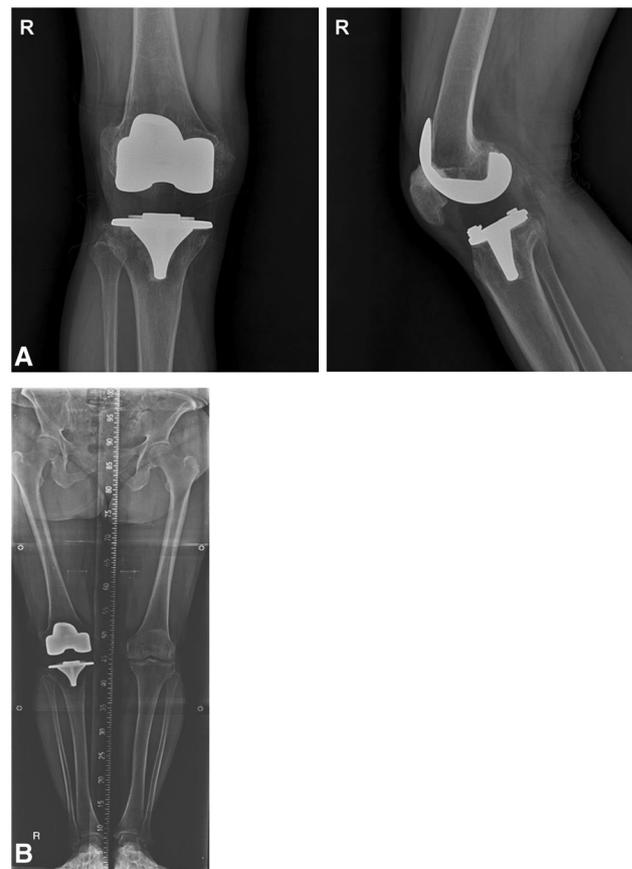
a Radiographs at final follow-up, well-fixed components with no signs of loosening. b Final follow-up scanogram shows maintained lower limb alignment
